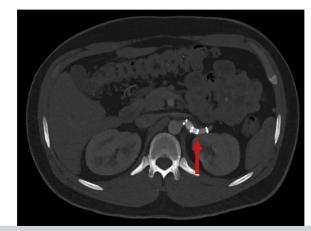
One-month postoperative computed tomography angiography (CTA) revealed successfully excluded left renal artery aneurysm (LRAA; *arrow*).
